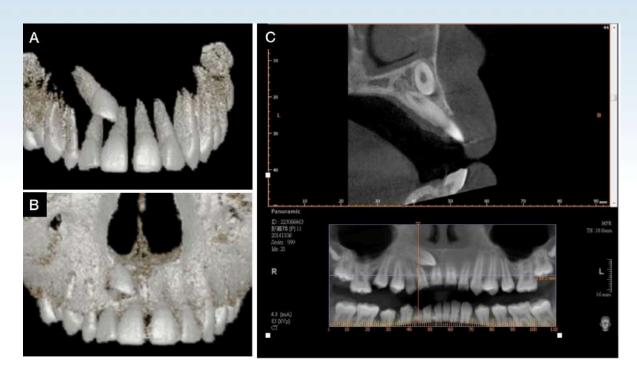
Pre-treatment CBCT
